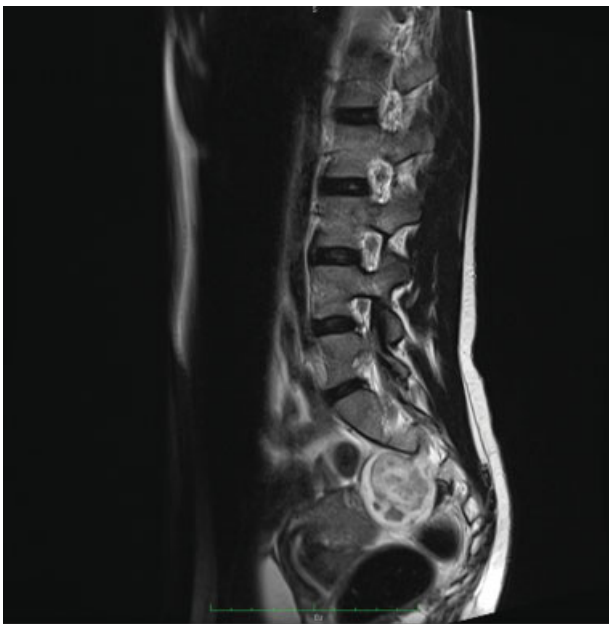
Lumbosacral spine contrast-enhanced magnetic resonance imaging. (A) Sagittal T2-weighted image showing tumor location in the presacral region.
